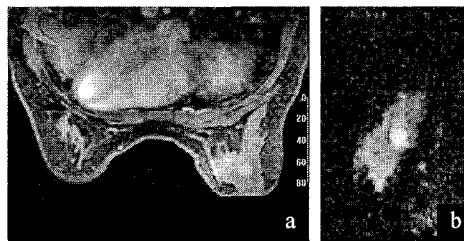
A medullary carcinoma in a 38-year-old patient. (a) contrast-enhanced MR. Axial plane. An enhanced nodule was clearly seen. (b) The nodule showed a high signal on DWI (Sagittal plane, b=1000), ADC=0.7373×10⁻³ mm²/sec
